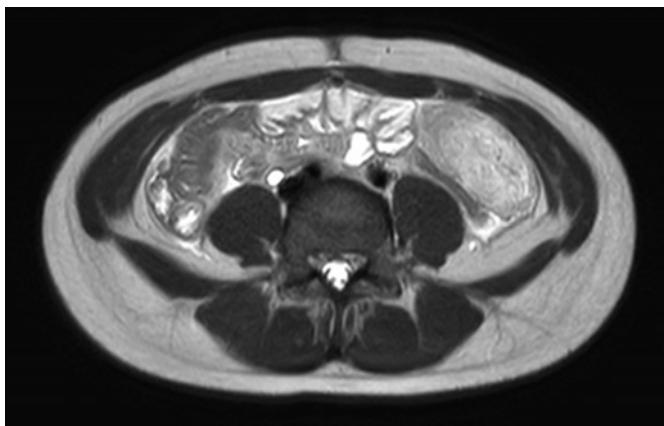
Abdominal MRI, T1-weighted image with contrast enhancement. A heterogeneously enhancing, poorly circumscribed mass lesion is seen in the left lateral abdomino-pelvic cavity. MRI, magnetic resonance imaging.
